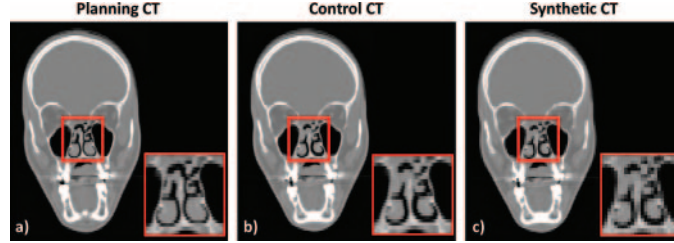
Same slice in the (a) planning, (b) control and (c) synthetic CT for one patient included in the study. The red box highlights the region of morphological change.
